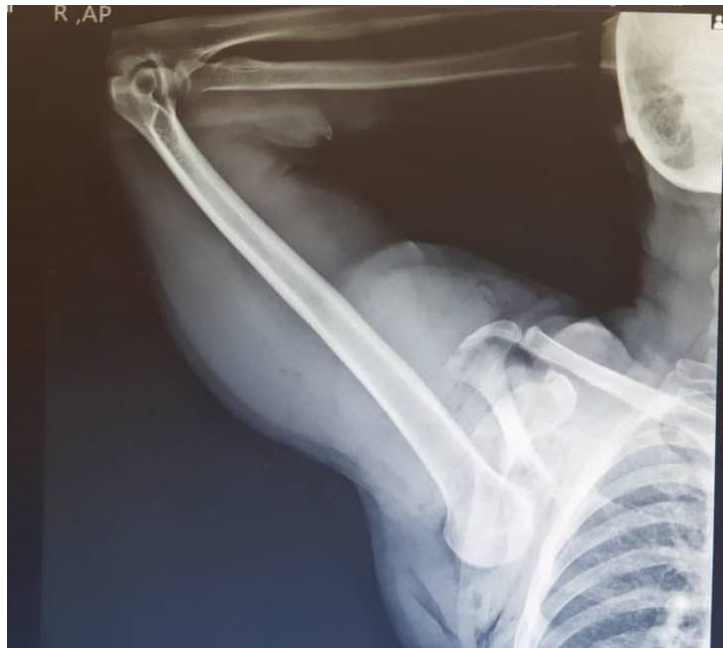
Pre-reduction radiography indicated inferior glenohumeral dislocation
